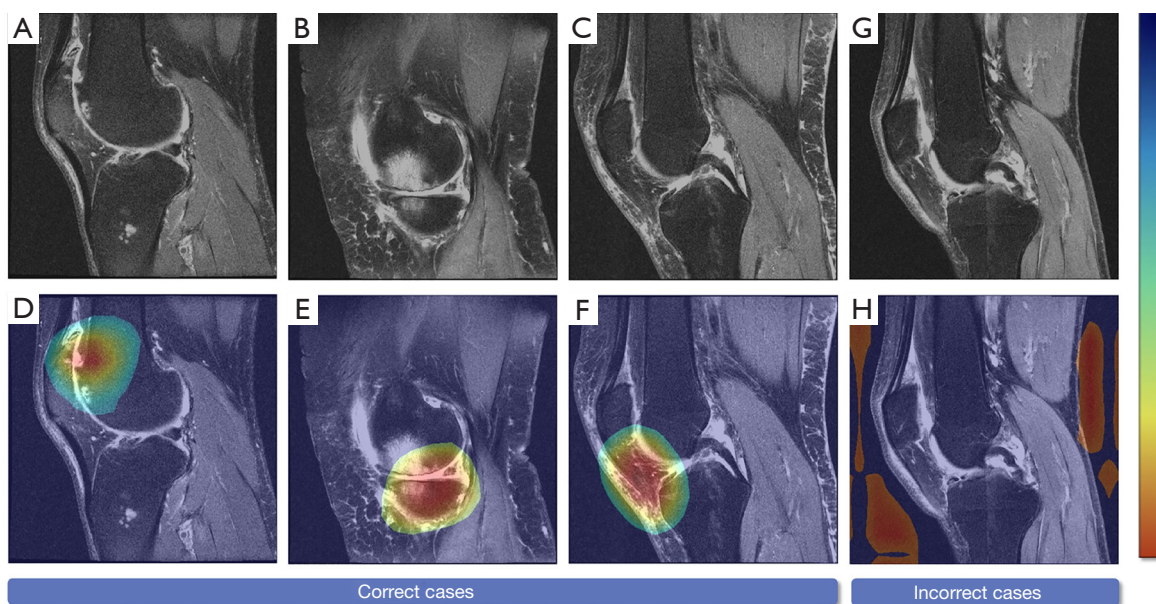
A visual comparison of attention maps generated by Grad-CAM between the properly anticipated cases (D-F) and the wrongly predicted cases (H). The first row represents the corresponding original MR images (A-C,G). (D-F) Shows cartilage damage and bone marrow lesions in the patellofemoral joint (D) and the tibiofemoral joint (E), as well as the infrapatellar fat pad (F) with changes that are beyond the human eye. (E) Simultaneously shows meniscal damage. Grad-CAM, gradient-weighted class activation maps; MR, magnetic resonance.
